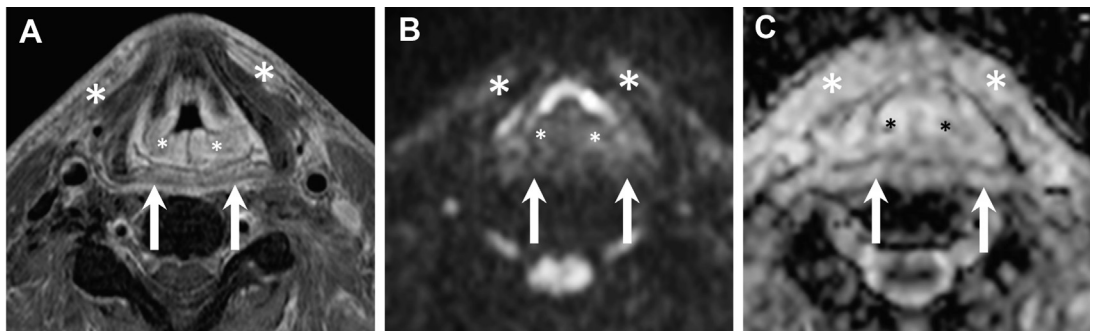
Characteristic MR imaging features of inflammatory edema after radiotherapy. MR imaging obtained 3 months after radiotherapy for an SCC of the supraglottic larynx. Axial contrast-enhanced fat-saturated T1 (A), b1000 (B), and ADC (C) images show bilateral and symmetric swelling of the aryepiglottic folds with strong contrast enhancement and without restricted diffusion (small asterisks on all figure parts) suggesting inflammatory edema. Note also inflammatory edema in the prelaryngeal strap muscles (large asterisks on all figure parts), as well as in the hypopharynx and retropharyngeal space (arrows).
